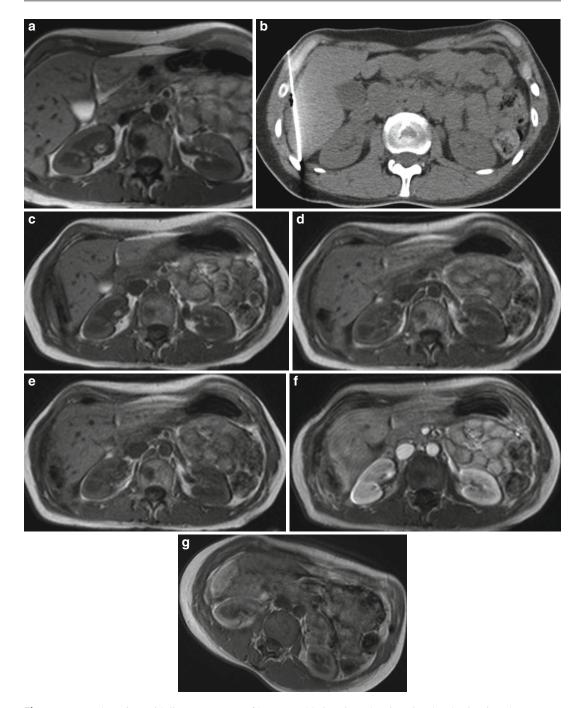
Female patient with liver metastases of breast cancer origin. (a) T1W1 before laser ablation showing a small lesion in the right lobe. (b) CT-guided puncture of the liver lesion. (c) T1W1 at the beginning of the ablation depicting two applicators placed in the center of the lesion. (d) After 19-min ablation time, signal reduction is shown. (e) T1W1 thermometry image after 21-min
